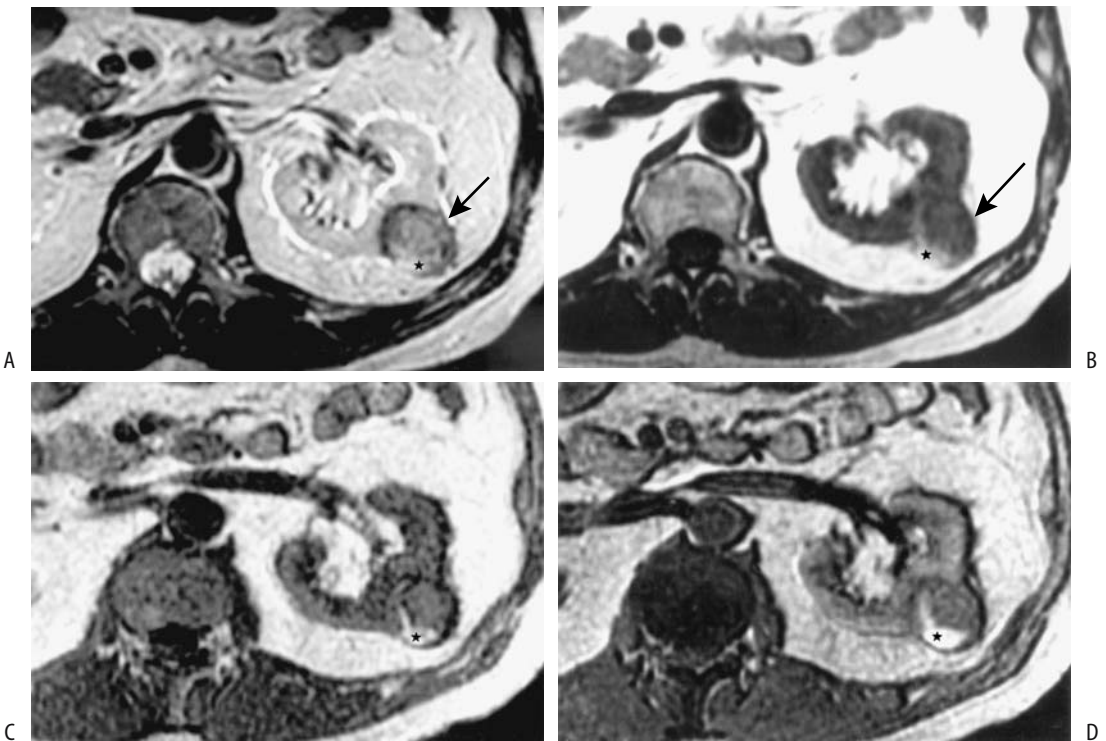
Magnetic resonance fat detection in clear cell renal cell carcinoma. T2-weighted fast spin echo (FSE) (A) and T1-weighted spin echo images (B) identify this tumor (arrow). In-phase (C) and out-of-phase (D) chemical shift gradient echo images show that it has a lower signal intensity on out-of-phase imaging. Chemical shift imaging helps identify fat within clear cell carcinomas, which differentiates these tumors from other carcinomas (Source: Yoshimitsu K, Honda H, Kuroiwa T, et al. Magnetic resonance detection of cytoplasmic fat in clear cell renal cell carcinoma utilizing chemical shift gradient-echo imaging. *J Magn Reson Imaging* 1999;9:579–585, with permission of Wiley-Liss, a subsidiary of John Wiley & Sons.)
